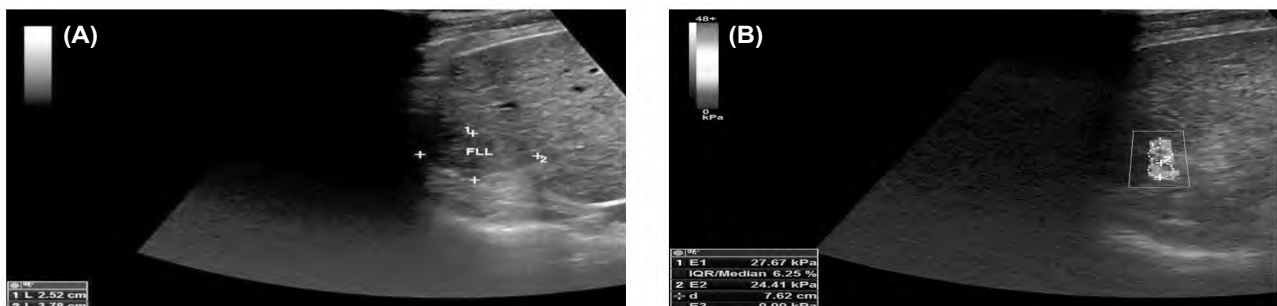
Hepatocellular carcinoma: A 65 years old male patient with HCV positive and elevated AFP. (A) Conventional ultrasound revealed enlarged liver with cirrhotic features. A well defined slightly hypoechoic right lobe focal lesion measuring about (3.7 x 2.5 cm.). (B) Shear wave elastography of the lesion showed heterogenous color within the color-coded shear wave box. It revealed that the median lesion stiffness was 24.41 kPa and the median parenchymal stiffness was 6.50 kPa (Metavir score F1 - mild liver fibrosis).
